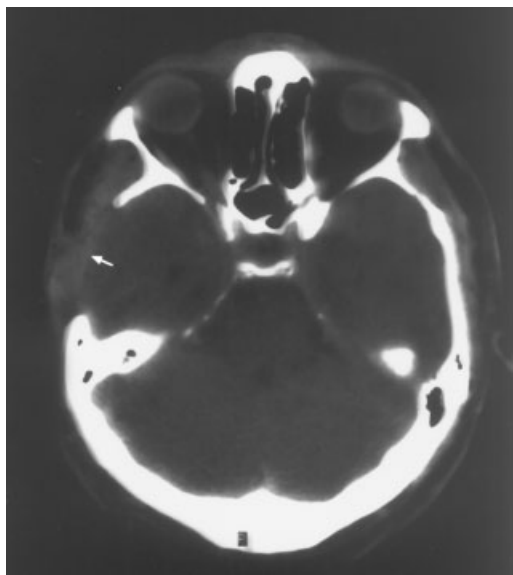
Axial computed tomographic scan after first operation.
